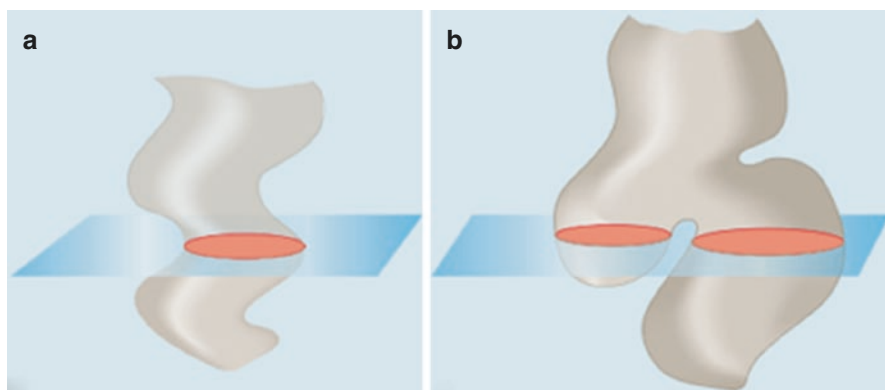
Subclassification of sigmoid-form achalasia. (a) Sigmoid type I (S1): the esophagus is significantly dilated and tortuous, but only a single lumen is seen on any computed tomography (CT) slice. (b) Sigmoid type II (S2). The esophagus is very dilated and tortuous and some CT slices show a double lumen
